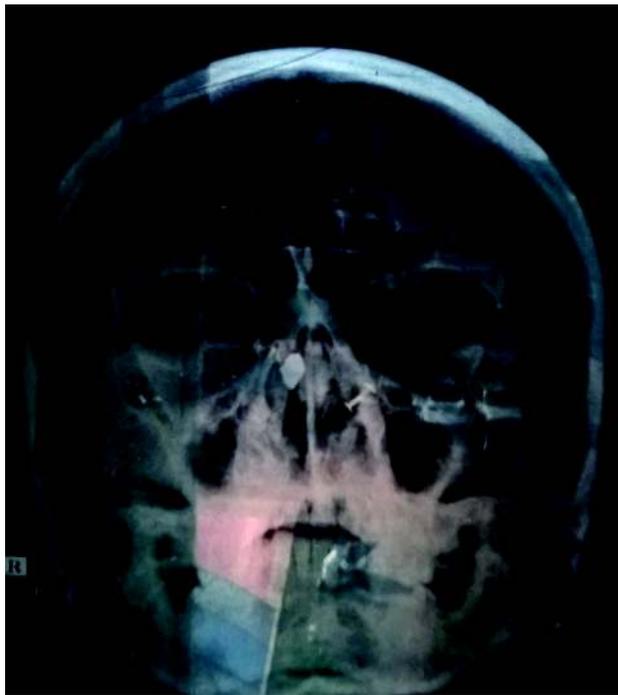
Plain X-ray PNS Water's View showing Radio-opaque Foreign body in Right nasal Cavity.
